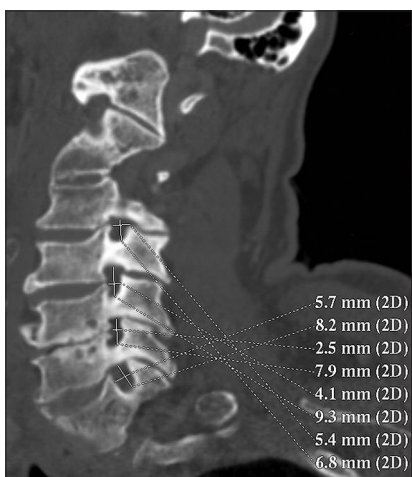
Computed tomography image with measurements
